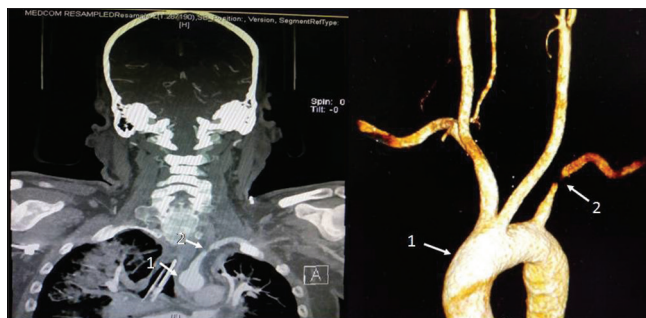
CT angiography and its 3D reconstruction showing arch of aorta (1) and left subclavian artery stenosis (2)
